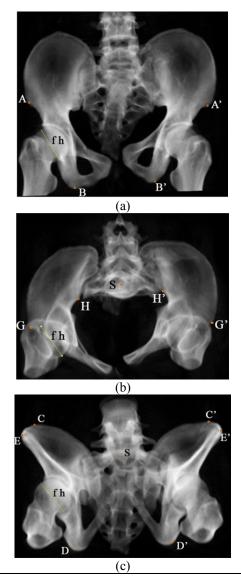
A computer aided measurement method for unstable pelvic fractures based on standardised radiographs (Zhao et al. 2015). (a) A-P view – ASIS: A and A'. Ischial tuberosity: B and B'.) (b) inlet view. ASIS: G and G'. H and H' anterior border of SIJ. S- sacral endplate (c) outlet view. C and C' ASIS. S and D and D' ischial tuberosity. All views: H = femoral head. Adapted from Zhao et al. 2015.
